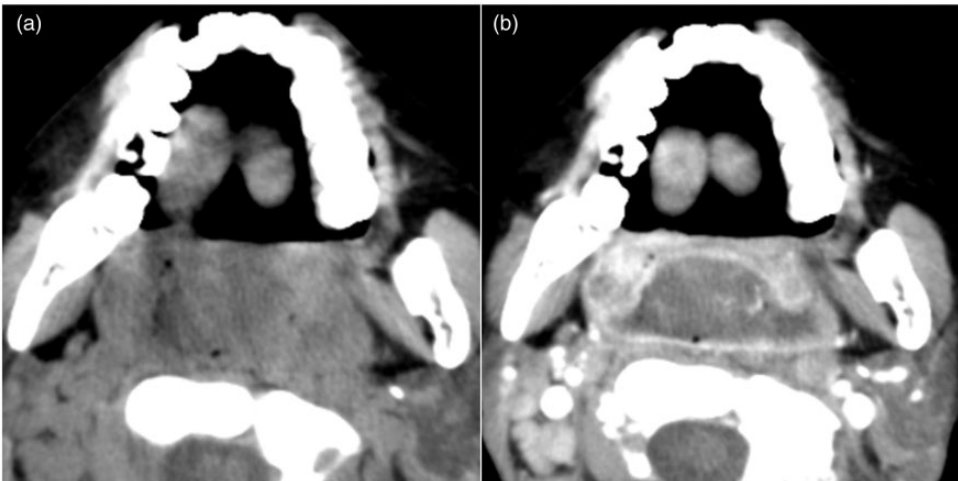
A 14-year-old female patient presented with a 7-day history of bilateral nasal obstruction and pharyngalgia and a 3-day history of fever. (a, b) Computed tomography images of the pharyngeal lesion (b, contrast-enhanced scan).
